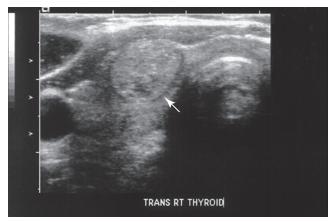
Transverse sonogram of the thyroid gland.
